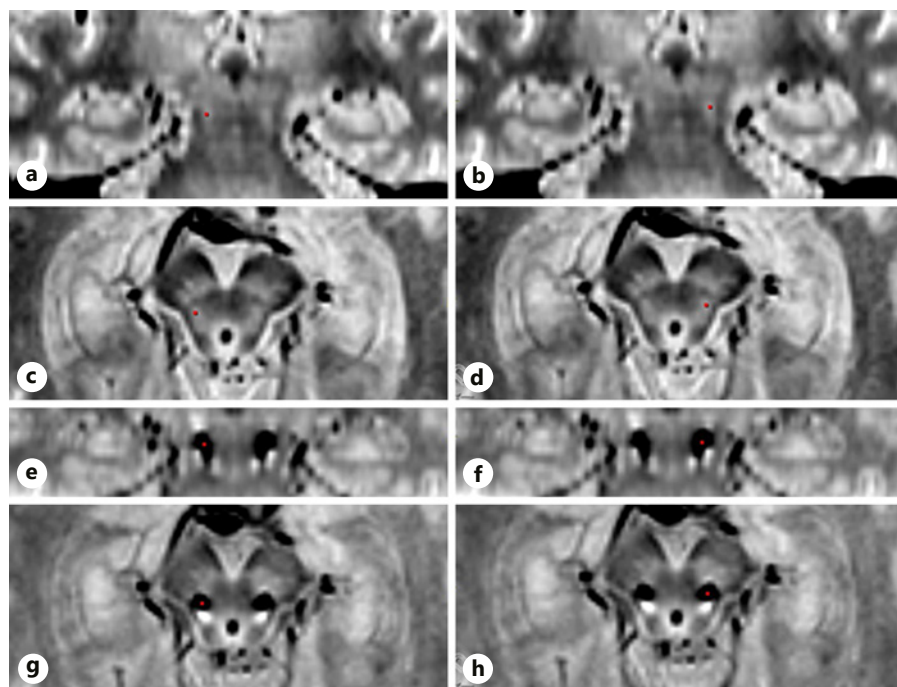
Proton density-weighted MRI for patient 6: right and left pre-operative coronal (a, b), axial (c, d) post-operative coronal (e, f), and axial (g, h). The red dot indicates the active contact in all images.
